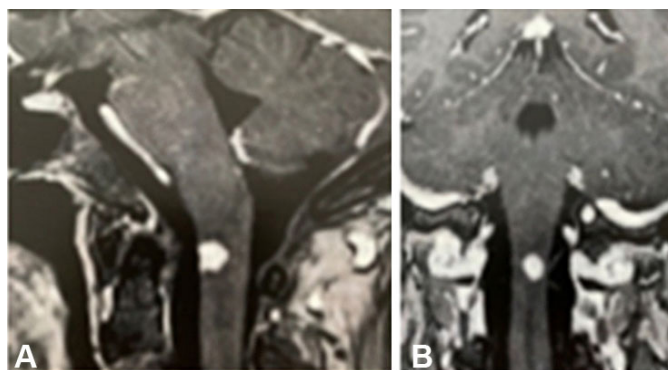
Magnetic resonance imaging showing a rounded intradural and intramedullary lesion, measuring approximately 1 cm in diameter, at level C1.
